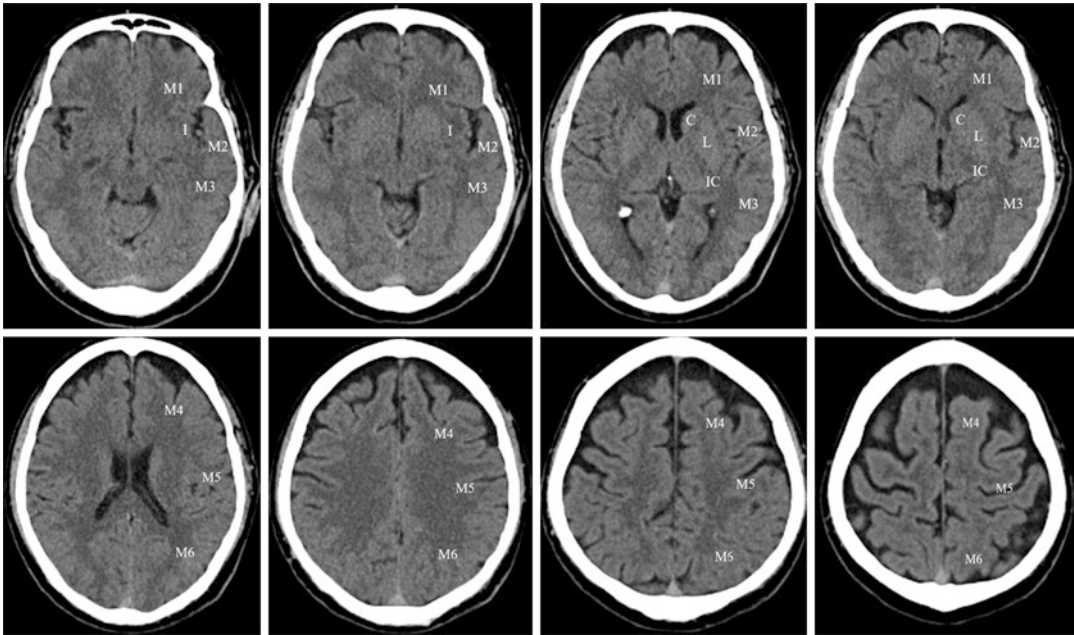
The MCA territory is divided into 10 ASPECTS regions: caudate (C), insular ribbon (I), posterior limb of internal capsule (IC), lentiform nucleus (L), anterior inferior frontal cortex (M1), anterior temporal cortex (lateral
